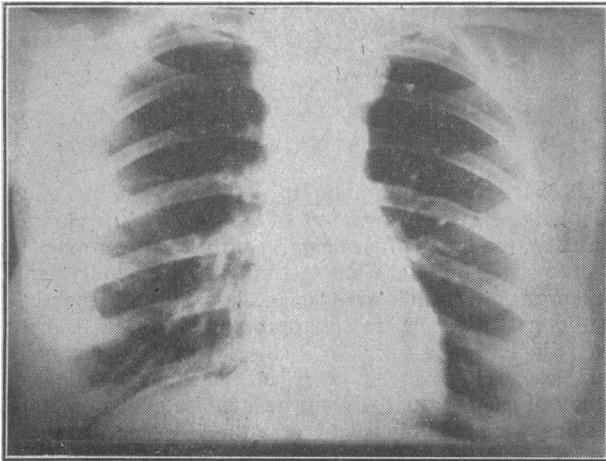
Case 2: Radiograph before treatment, showing enlarged left mediastinal lymph nodes.
